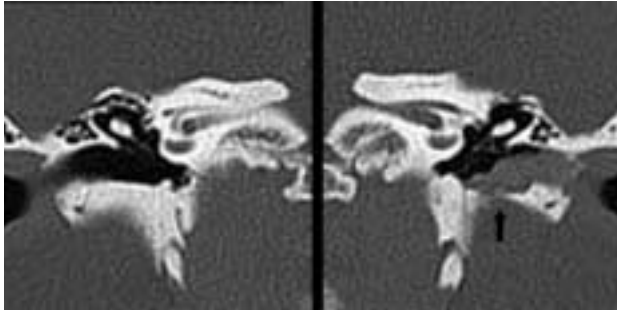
Axial temporal bone CT of patient 1: soft-tissue mass occupying the whole length of the left EAC, with signs of bone erosion in the inferior wall (arrow).
